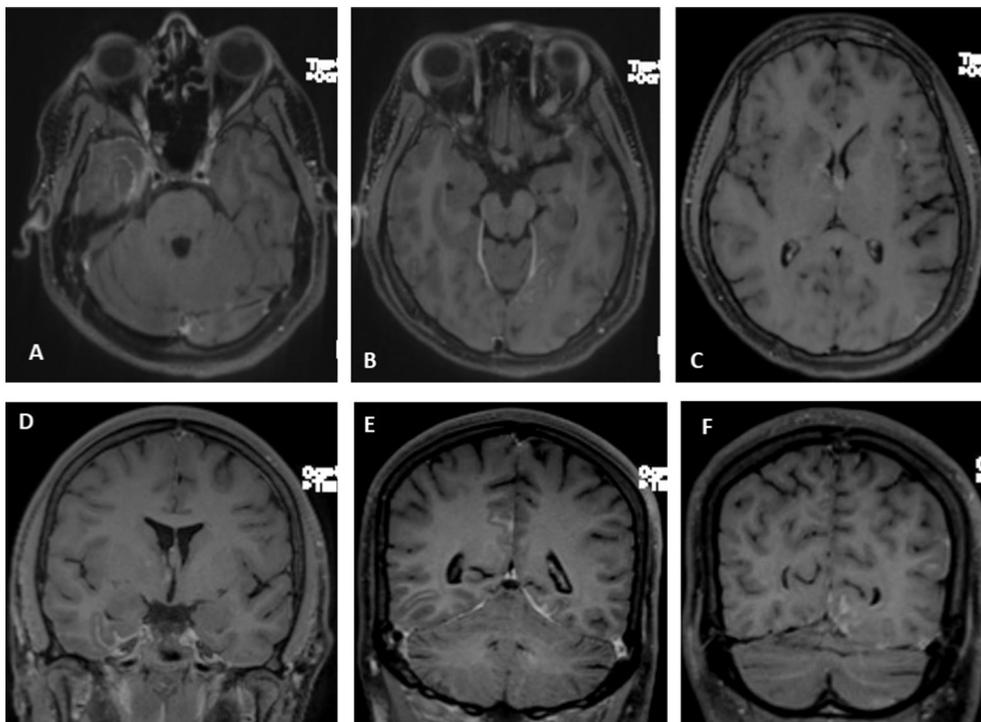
2A-2C: Post contrast T1 axial images: Note the leptomeningeal enhancement along the medial temporal region and along the anterior temporal pole. There is definite pachymeningeal enhancement along the tentorium (B). There is patchy enhancement in the right caudothalamic region and the left insular region – in the areas corresponding to the FLAIR hyperintensity in Fig. 1C. 2D-2F: Post contrast T1 coronal images show the right temporal leptomeningeal enhancement (D), tentorial enhancement along the left side and the sulcal enhancement in the right parieto-occipital region (E) and left occipital region (F).
